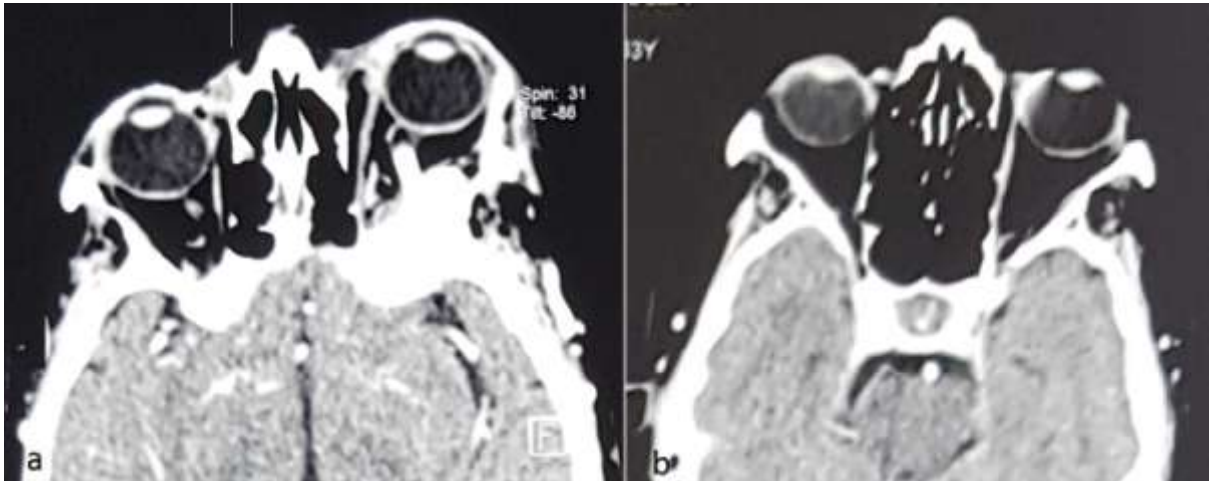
Orbital CT showing: a) a cavernous hemangioma of the left eye; b) complete regression of cavernous hemangioma.
